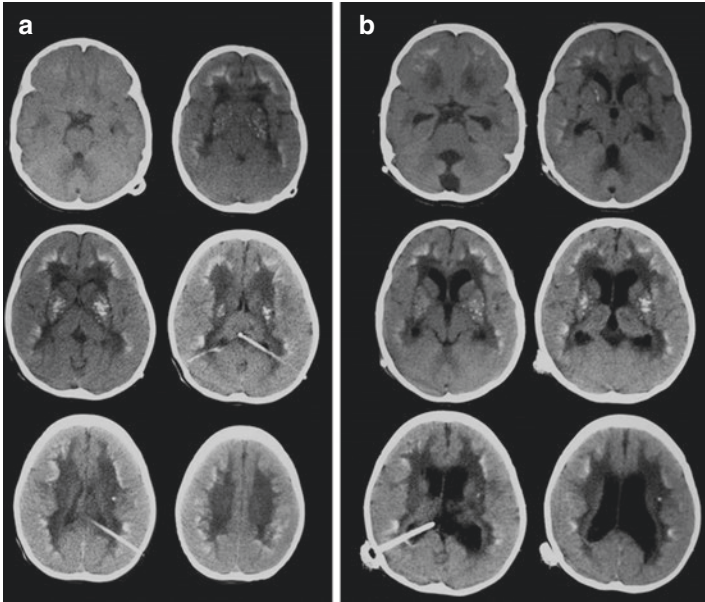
Non-contrast brain CT scan showing two scans (a and b) from a patient with a ventriculoperitoneal shunt. It is important to note that there is pan ventricular dilatation in (b) with obvious dilatation of the temporal horns and third ventricle due to shunt malfunction. In less obvious cases a detailed comparison of the previous scan (a) with the new scan (b) is essential
